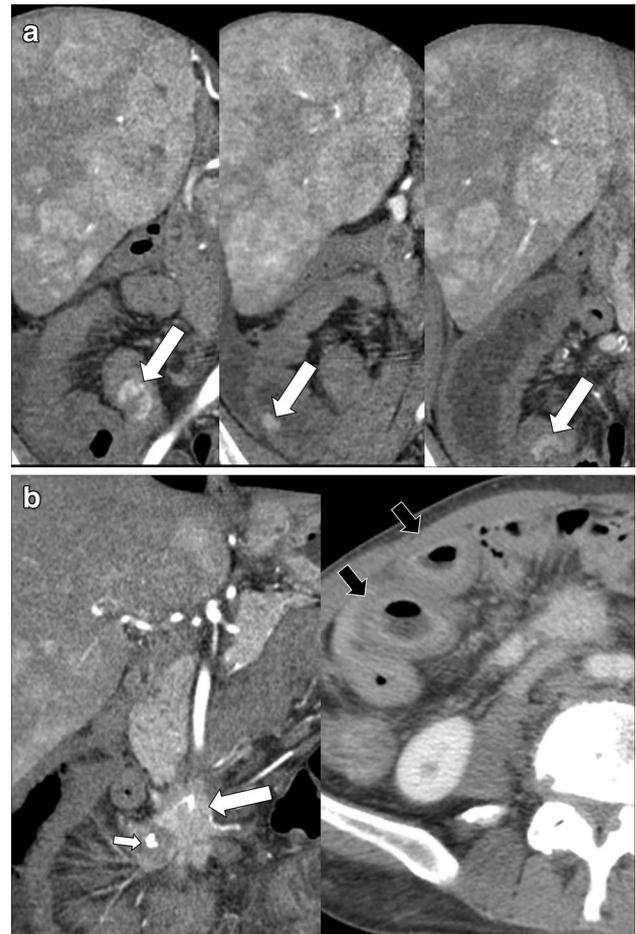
A 52-year-old man presenting with diarrhea, flushing, weight loss and abdominal discomfort. a Serial CT coronal images on arterial phase show multiple small enhancing masses in the ileum (arrows). Note multiple hypervascular metastatic masses in the liver. Liver target biopsy for the mass revealed a neuroendocrine tumor (G1). b CT coronal image shows an irregular enhancing mass encasing the mesenteric artery with luminal stenosis (arrow, left). There is a small calcification in the mass (small arrow, left). Axial enhanced CT image shows layered-wall thickening of the right sided, ileal loop due to mesenteric arterial stenosis, indicating ischemic enteritis (black arrows, right)
